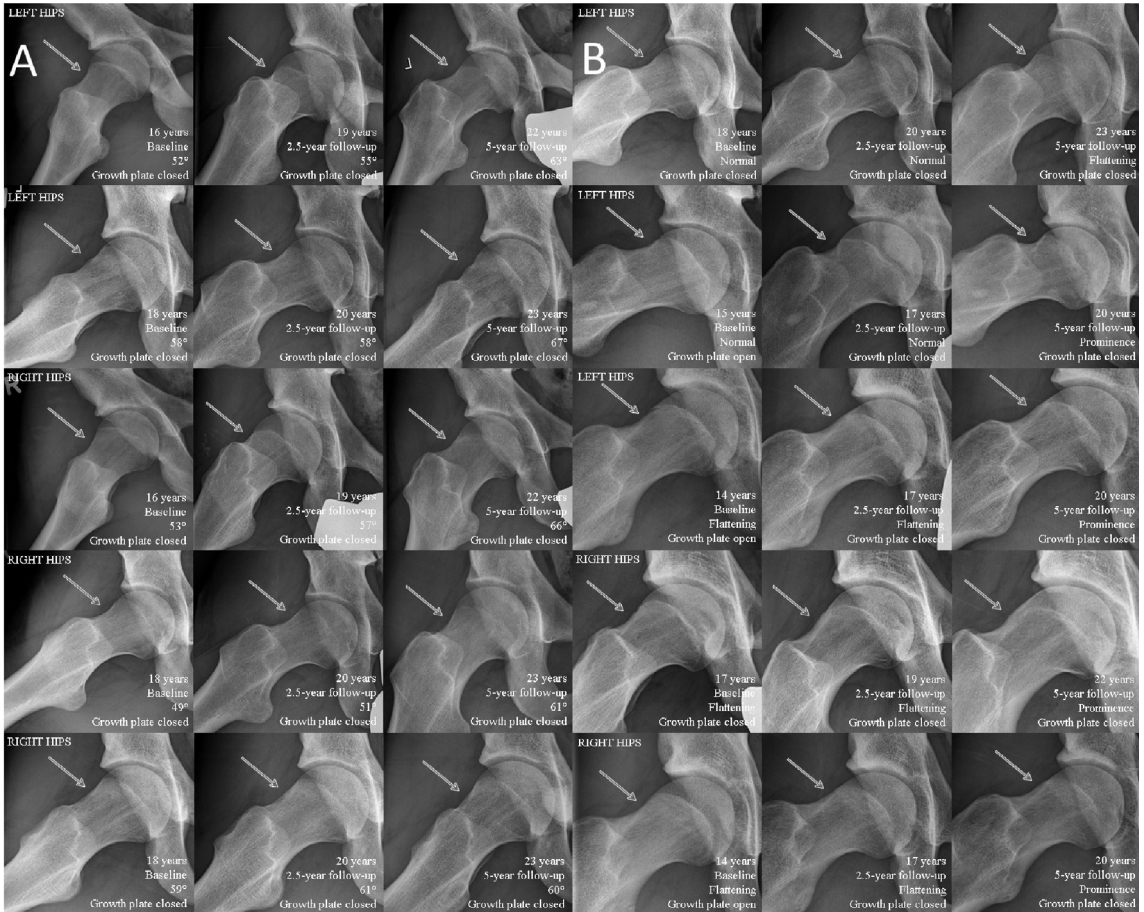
Cam morphology development (based on alpha angle (A) and visual score (B)) possibly caused by hip rotation (visible via greater trochanter projection) on frog-leg lateral radiographs. (A) Besides differences in rotation, the alpha angle increased with $\leq 10^\circ$ from 2.5-year follow-up to 5-year follow-up in these hips. (B) Very subtle change in visual score was observed at 5-year follow-up while the femoral head-neck junction was normal or flattened at baseline and 2.5-year follow-up. This change in visual score is possibly due to the slight difference in rotation during the follow-up times.
